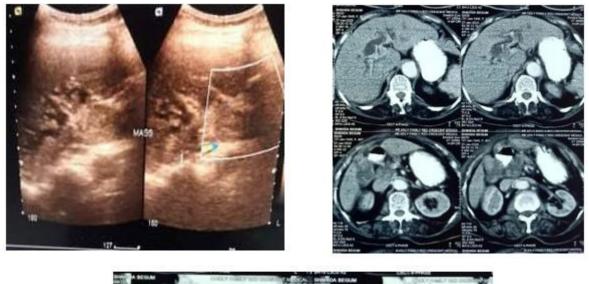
Ultrasound image reveals contractedGB with soft tissue mass within its lumen, soft tissue mass in porta hepatis with focal compression and invasion, intrahepatic biliary dilatation with suspected mass is CBD, and dilated MPD
